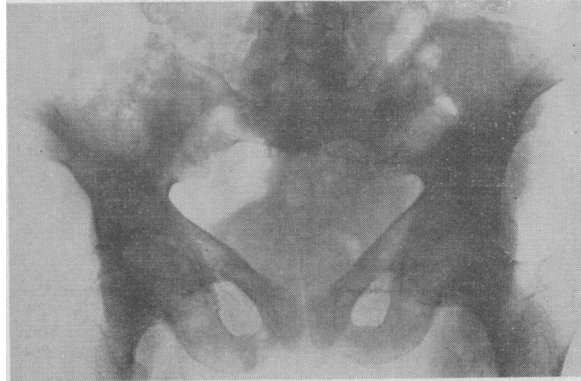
Radiograph of pelvis of a woman with steatorrhœa and osteomalacia of sudden onset, and with tetany. The bones are almost normal in shape, but show Looser zones in the pubic rami.
